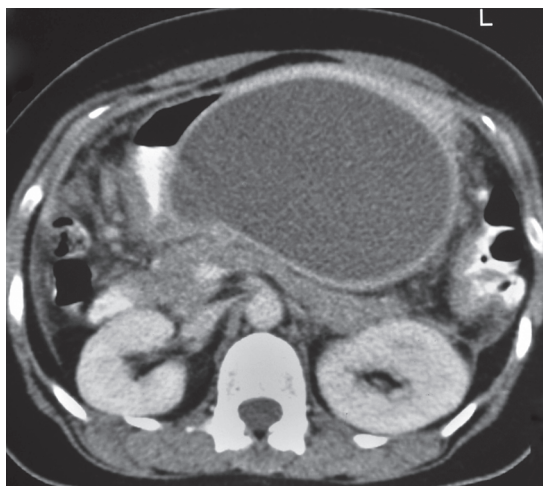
Computed tomography: large collection in the less sac
